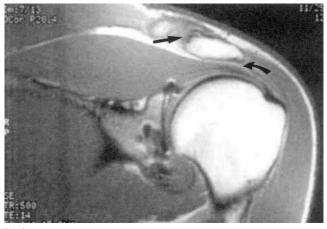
T1-weighted coronal magnetic resonance imaging demonstrating signal irregularities of the supraspinatus tendon* (curved arrow). Also note low signal changes of the acromion, representing degeneration of the acromioclavicular joint (arrow).
